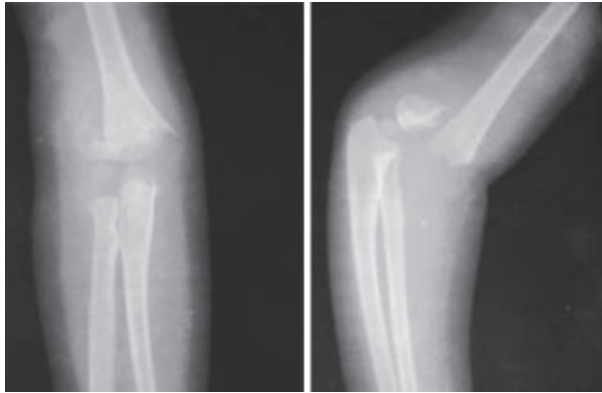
Preoperative x-ray of 8 years old boy
